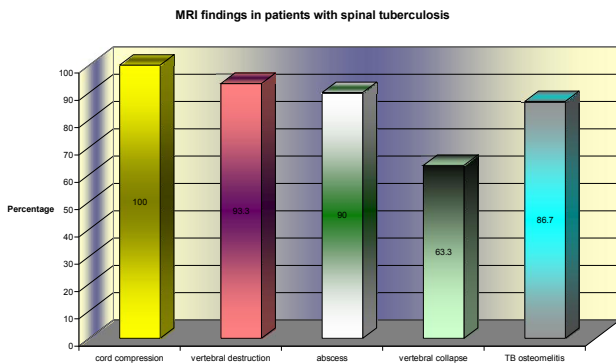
shows MRI findings in Pott's disease
